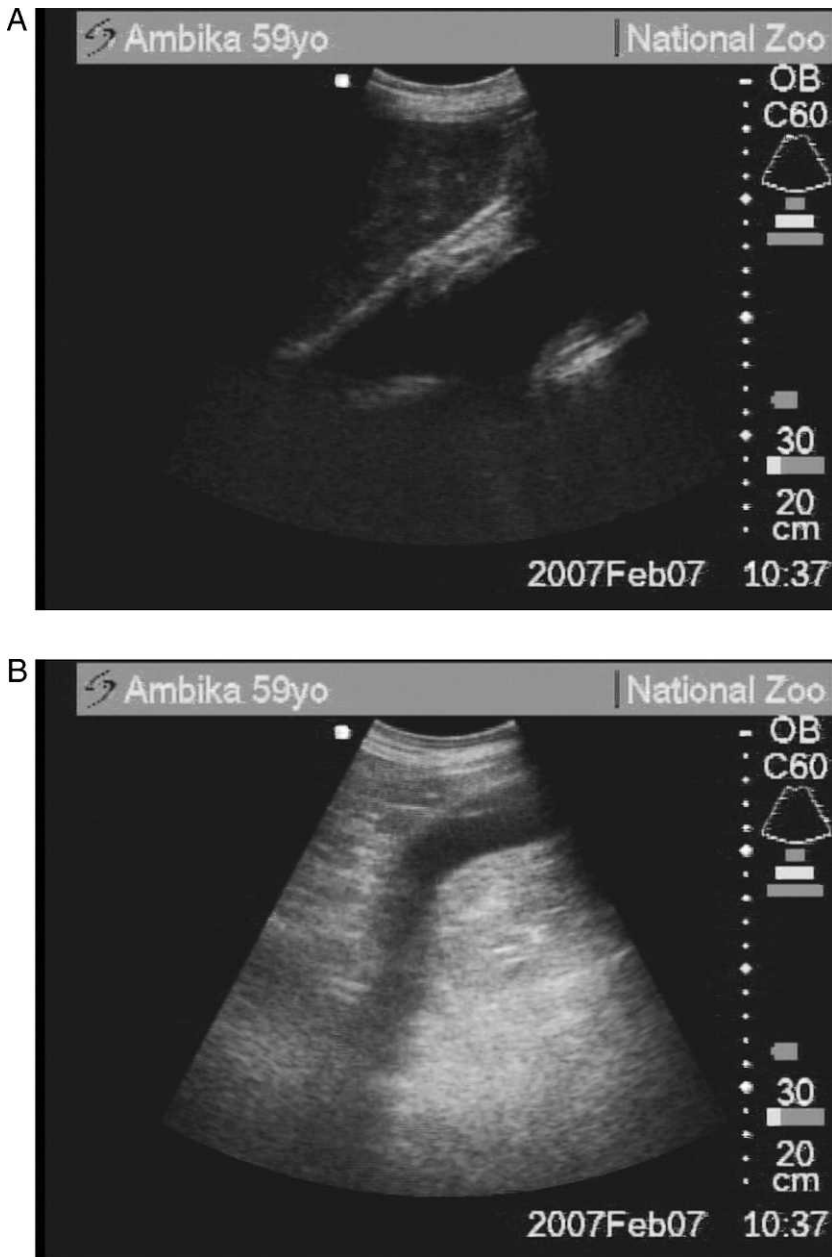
Ultrasound images from the 7 February 2007 examination, showing (A) the distended vaginal canal at the top of the image and a suspected blood clot enlarging to the left from the cervix with the urinary bladder below and (B) an enlarged blood vessel adjacent to the distended vagina. Images provided by Dr. Dennis Schmitt.
